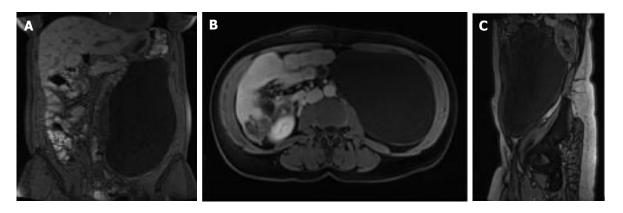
A pelvic magnetic resonance imaging scan confirming the intra-abdominal nature of the cyst, and ruling out a retroperitoneal origin, i.e., an ovarian cyst.
